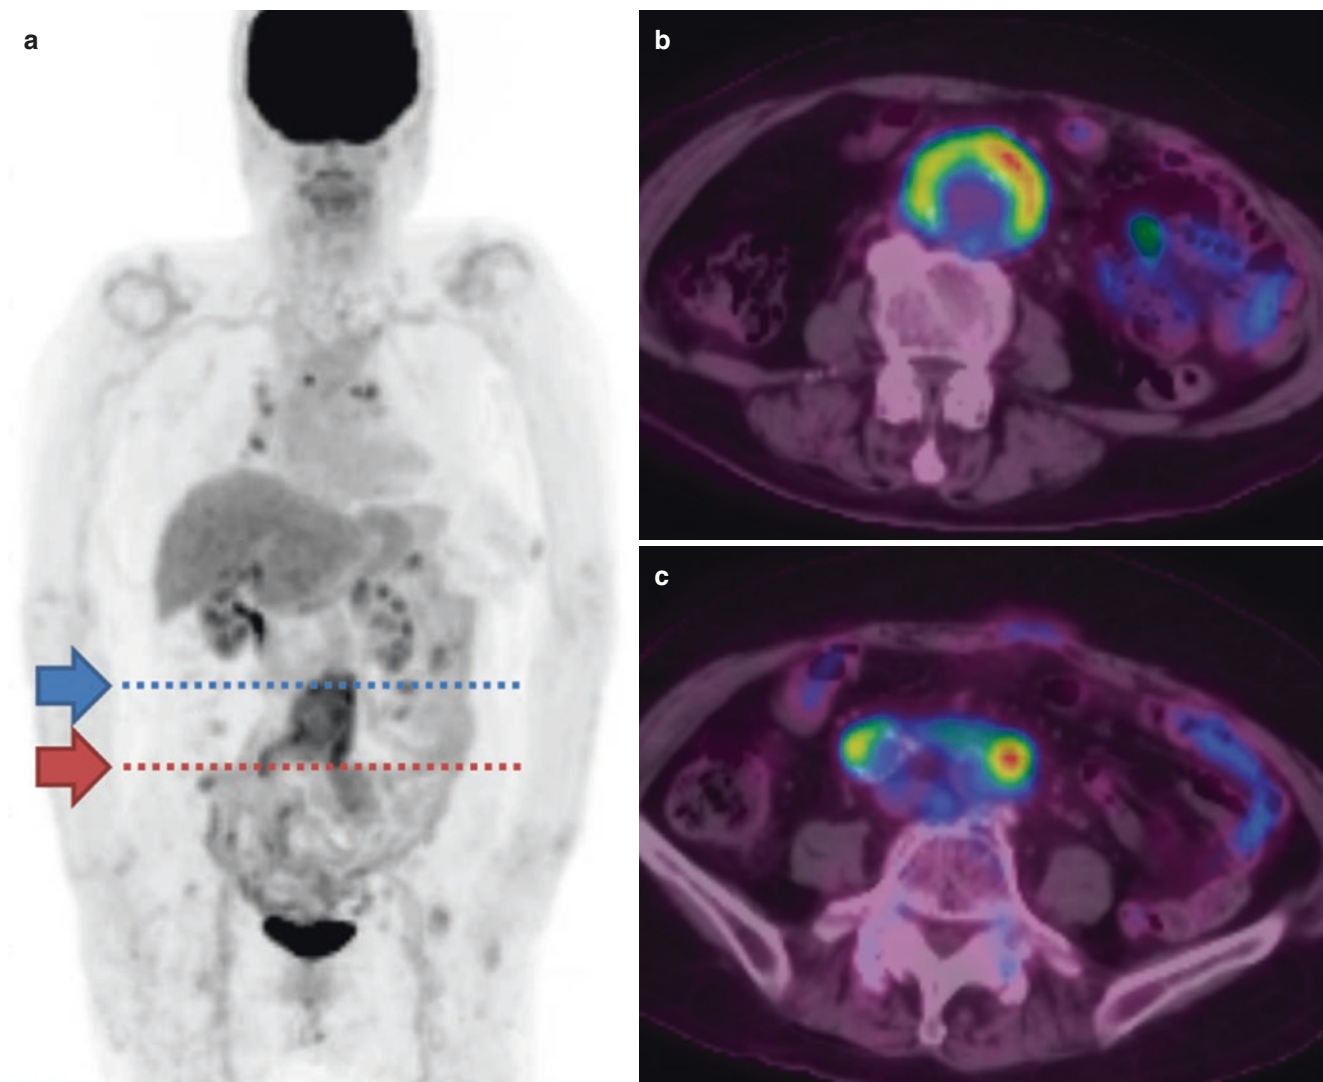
Maximum intensity projection image (a) and axial fused images at AAA (b, blue arrow level) and common iliac arteries (c, red arrow level) are displayed. Strong focal uptakes on AAA ($SUV_{max} = 4.9$) and common iliac arteries ($SUV_s = 5.9$) which represented the active
